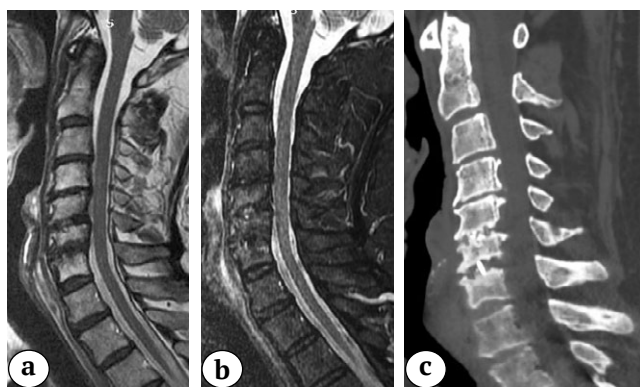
MRI (a – T2 images; b – STIR images) and CT (c) after the first operation: two interbody implants (PEEK cages) are identified at the C5–C6, C6–C7, C4–C6 ossification of the posterior longitudinal ligament (segmental type according to the Committee on the Ossification of the Spinal Ligaments)
